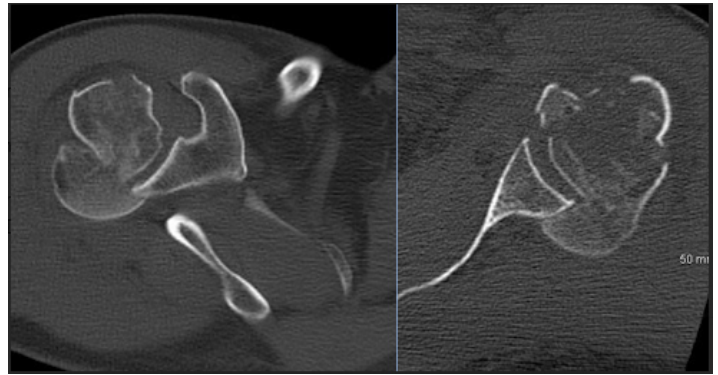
Axial CT slices of the right and left Shoulders at the level of the Humeral head.
